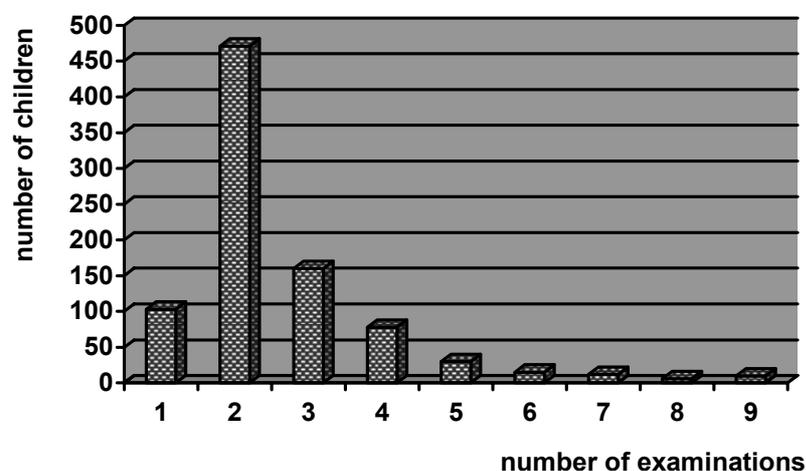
The distribution of the X-rays examinations performed per child.
